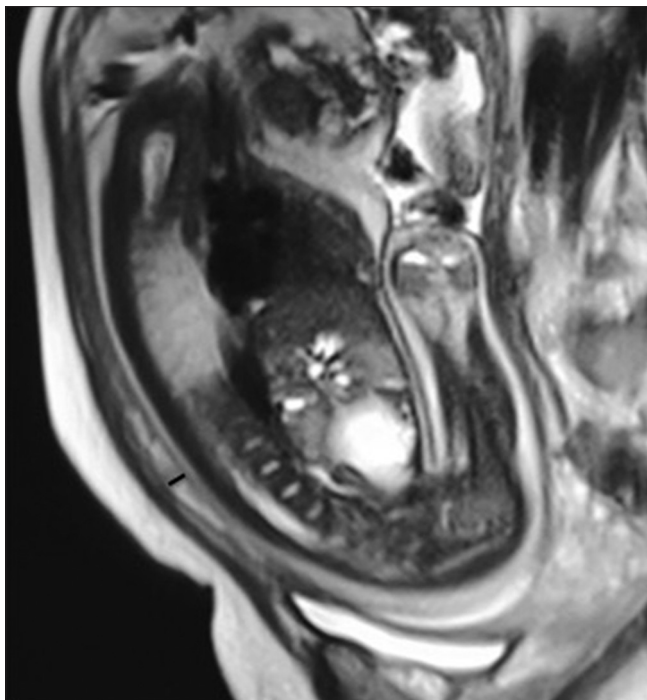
T2-weighted mid-sagittal image showing hyperintense scar and thickness measured at its thinnest portion
